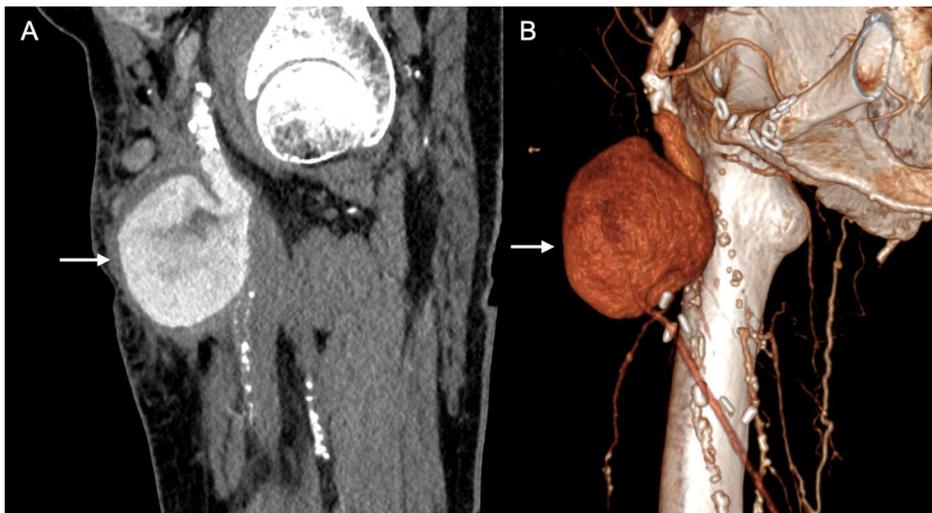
A 58-year-old man who attended with a tumour-like lesion in the right inguinal region of one week's duration following femoropopliteal bypass surgery. Coronal (A) and 3D (B) CT angiography reconstructions of the right thigh in arterial phase, showing a giant pseudoaneurysm (arrow) located at the anterior margin of the bifurcation of the common femoral artery, at the level of the proximal anastomosis of the femoropopliteal graft.
